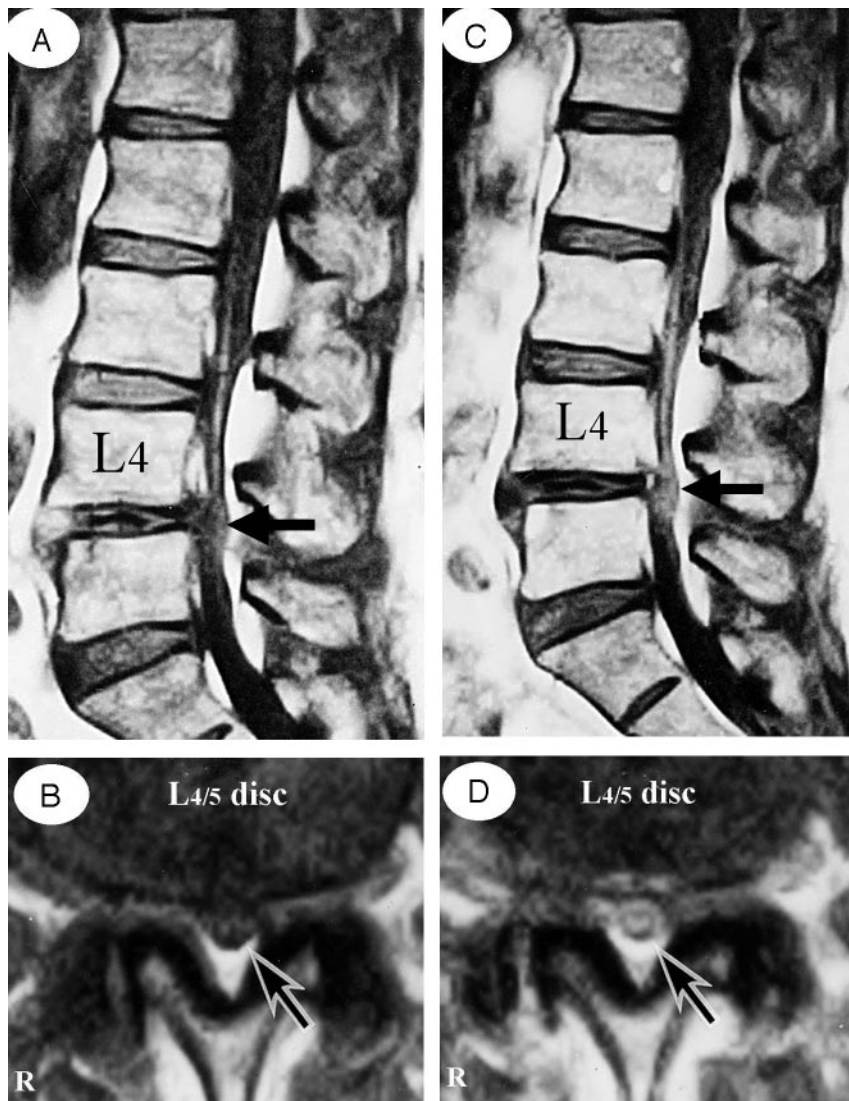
A 73-year-old man complained of weakness and numbness of the lower extremities after walking about 300 meters, but no obvious sensory loss and muscle weakness were noted. A and B, Precontrast T1-weighted (500/35) sagittal (A) and axial (B) conventional spin-echo MR images indicated a diagnosis of LSCS at L4/5 disk level (arrows). C and D, T1-weighted (500/35) sagittal (C) and axial (D) MR images acquired at L4/5 disk level obtained after 0.1 mmol/kg intravenous Gd-DTPA administration showing the generalized central canal stenosis as well as punctuate areas of intrathecal enhancement (arrows), which indicates a breakdown in the blood-nerve barrier.
